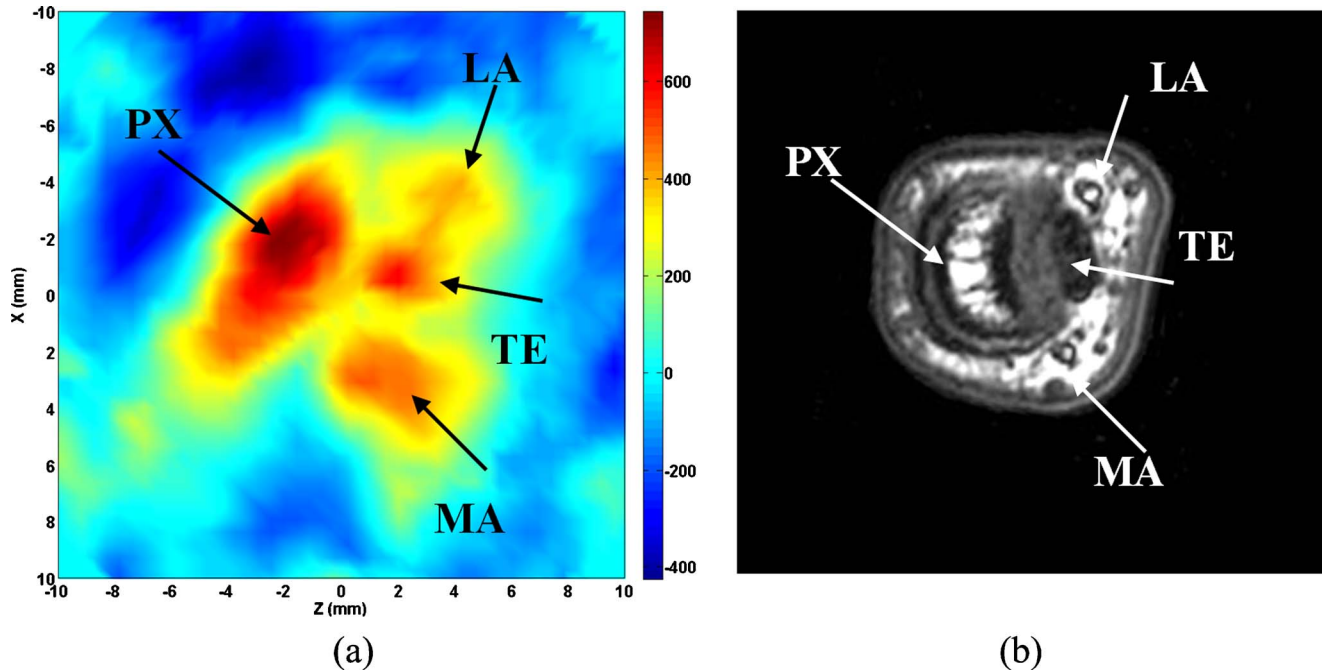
Selected cross section from the reconstructed 3-D image (absorbed energy density) at $y=7$ mm (a), and MRI (cross section) from a similar joint (b). PX: phalanx; MA: median artery; TE: tendon; LA: lateral artery.
